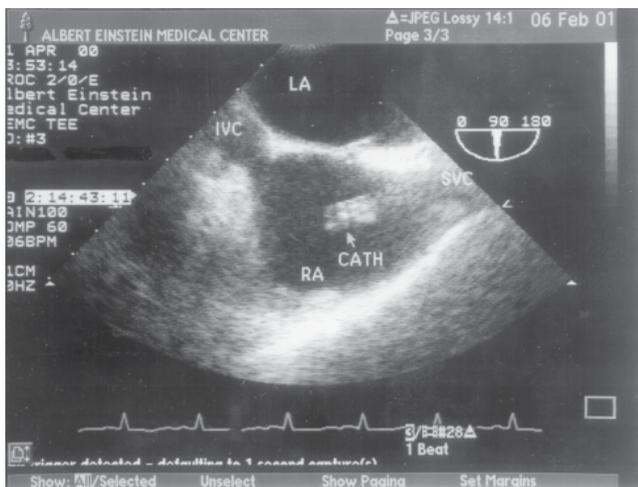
Trans-esophageal echocardiography of the patient in Fig. 1 after 8 weeks of anticoagulation; the tip of the dialysis catheter is visible in the right atrium, which is free of thrombus. RA = right atrium; LA = left atrium; IVC = inferior vena cava; SVC = superior vena cava; CATH = tip of dialysis catheter.
